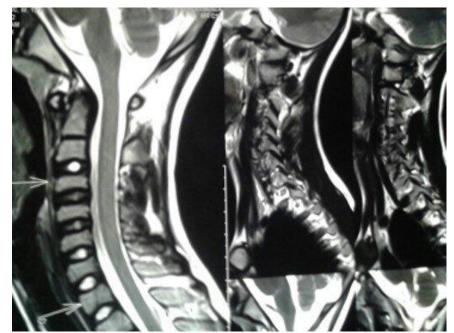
MRI cervical spine showing no feature of myelopathy
